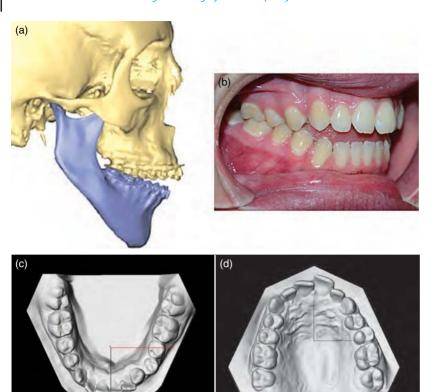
Apertognathia with two planes of occlusion. (a) Lateral 3D CT view with discrepant maxillary and mandibular occlusal planes and an open bite; (b) clinically, the presence of an anterior open bite. Digital models, to assess and measure a Bolton discrepancy; (c) lower model; (d) upper model.
